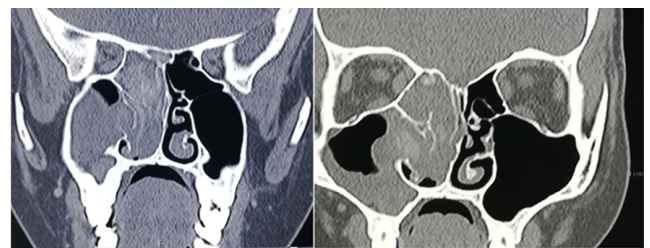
Coronal section of Computed Tomogram showing soft tissue opacification of right maxilla and ethmoid sinuses
